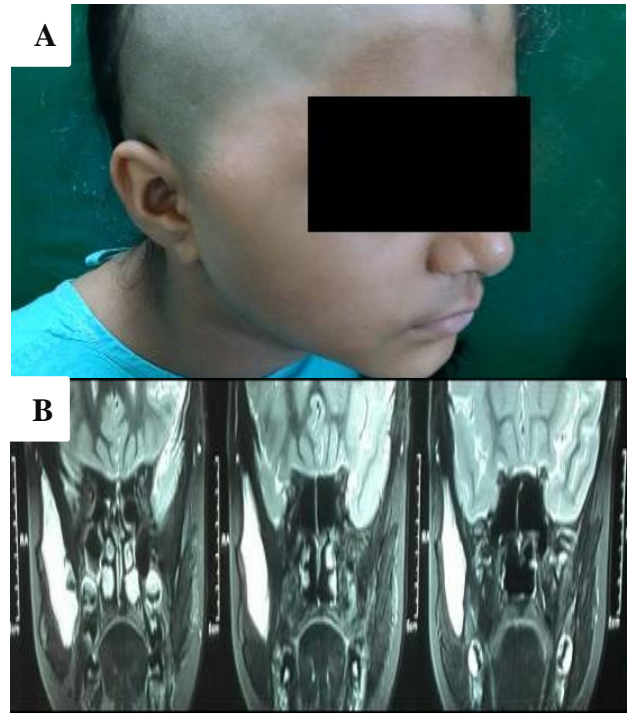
A & B: Right retro-zygomatic high flow vascular malformation involving pterygopalatine fossa and temporalis region in a 7-year-old female child, MRI.
